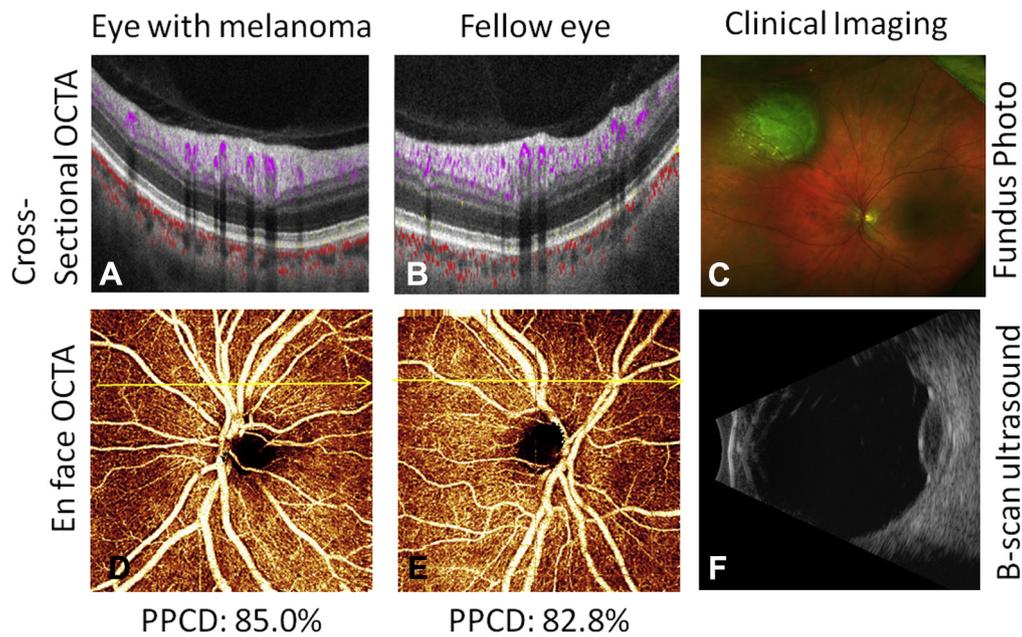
Representative example of peripapillary capillary density (PPCD) before treatment in an eye with uveal melanoma located in the superonasal periphery as compared with the normal fellow eye. A, B, Cross-sectional OCT angiography (OCTA) image for each eye (retinal flow shown in purple, and choroidal flow shown in red). D, E, En face OCTA of the peripapillary region. The location of the cross-sectional OCTA image is indicated with a yellow arrow. The PPCD for each eye is shown. The clinical imaging included (C) Optos fundus photography and (F) longitudinal B-scan ultrasonography.
